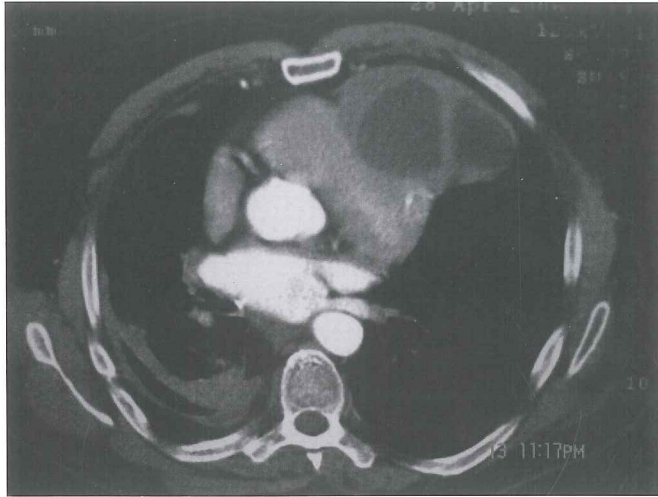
Spiral CT of the chest revealed cystic masses related to the supero-anterior aspect of the right and left ventricle, and right pleural thickening with minimal effusion.
